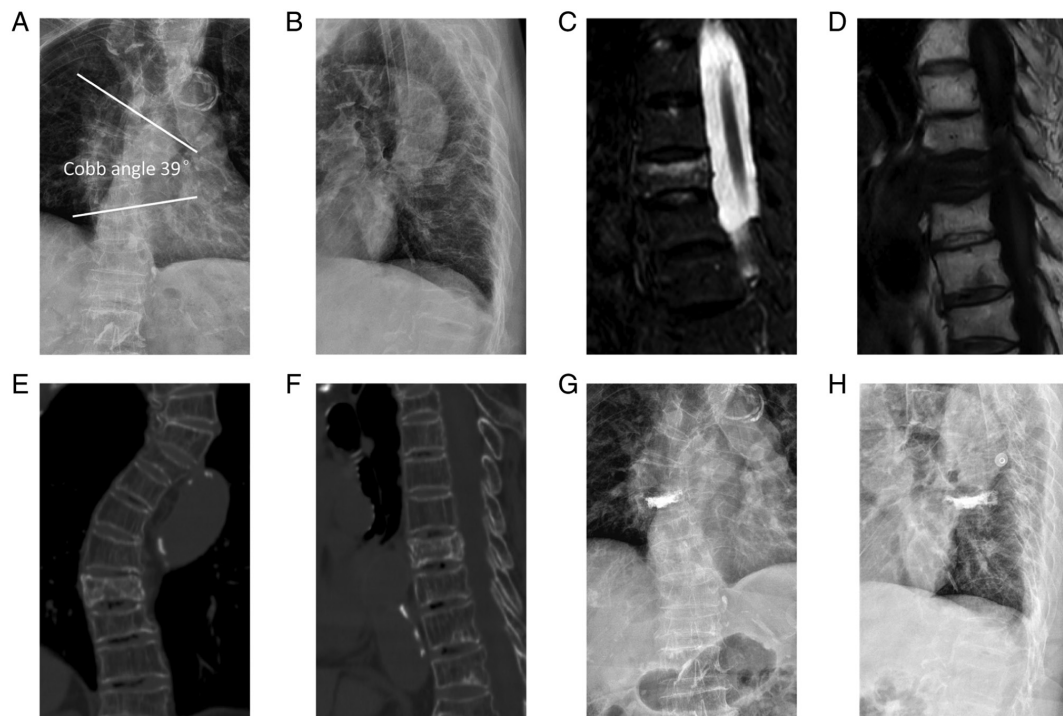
X-ray, MRI and CT images of an 85-year-old female patient with OVCF accompanied by spinal scoliosis treated by unilateral kyphoplasty. Preoperative X-rays of (A) anteroposterior and (B) lateral views showing scoliosis and OVCF. (C) Preoperative sagittal T2-weighted MRI showing high signal of short-TI inversion recovery sequence change on T9 vertebra. (D) Preoperative sagittal T1-weighted MRI showing low signal change on T9 vertebra. Preoperative (E) sagittal and (F) coronal CTs showing OVCF of T9 with scoliosis. Postoperative 1-day X-rays at (G) anteroposterior and (H) lateral view showing accepted unilateral kyphoplasty, good positioning of the bone cement without leakage and partial recovery of the vertebral height and kyphotic angle. OVCF, osteoporotic vertebral compression fractures.
